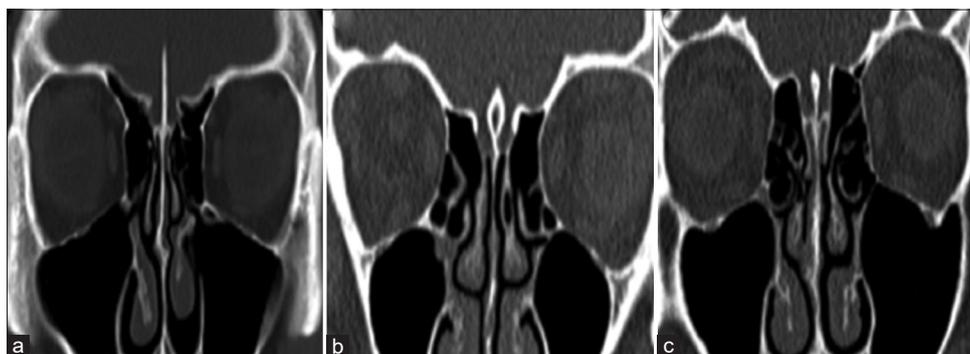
Computed tomography scan showing the Keros classification; (a) Keros Type I (b) Keros Type II (c) Keros Type III
